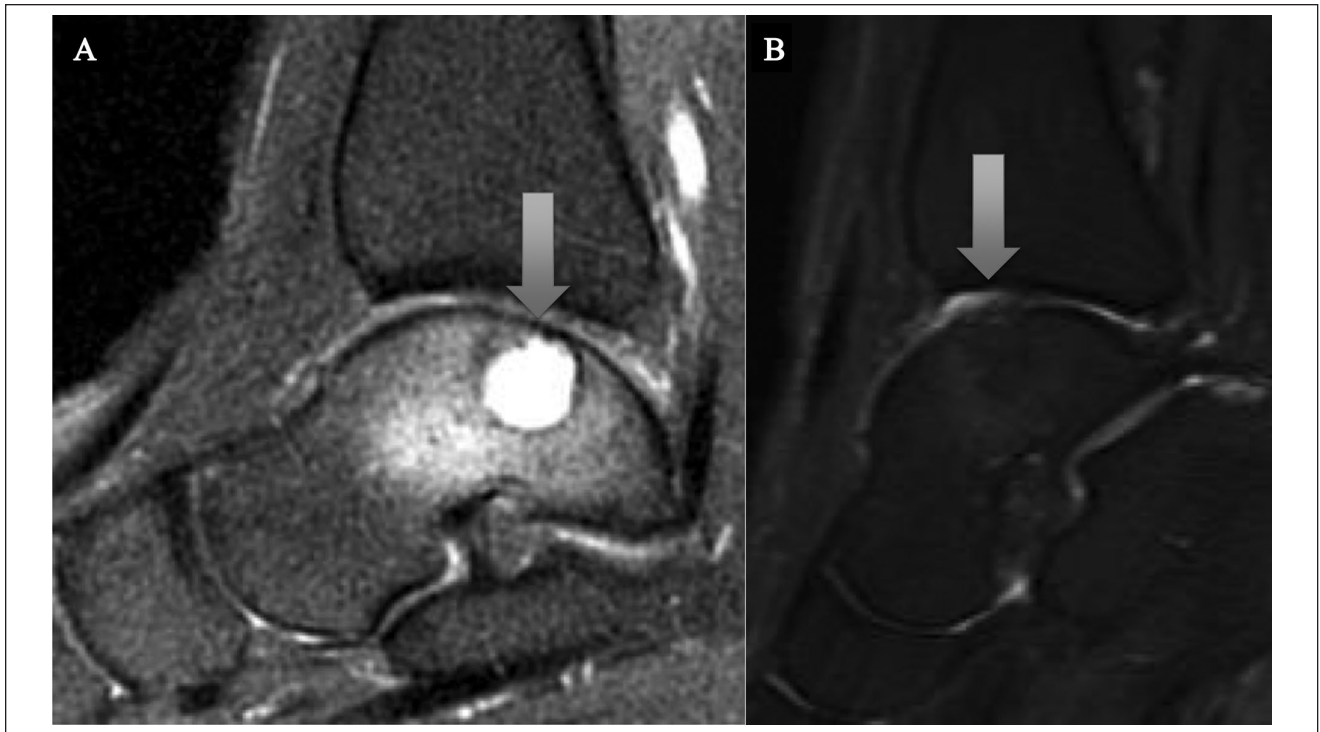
Magnetic resonance imaging (MRI) of same patient before and after operation. (A) Preoperative MRI of patient with a large osteochondral lesion of the talus, (B) postoperative MRI 2 years after particulated articular cartilage allograft transplantation.
